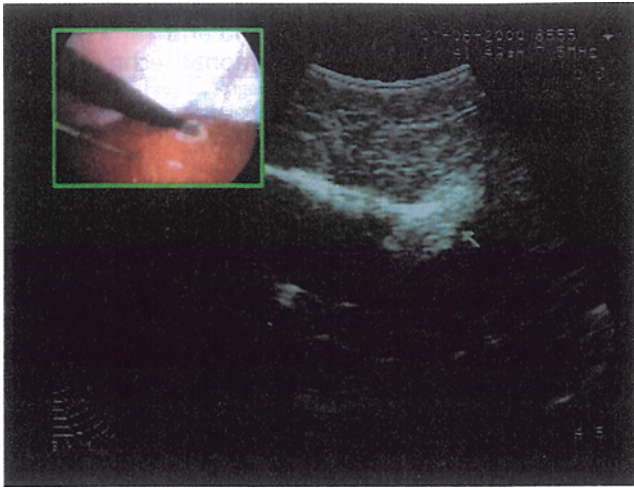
Laparoscopic and sonographic views of RF ablation probe placement in the longitudinal plane (arrow indicates tumor-mimic).
